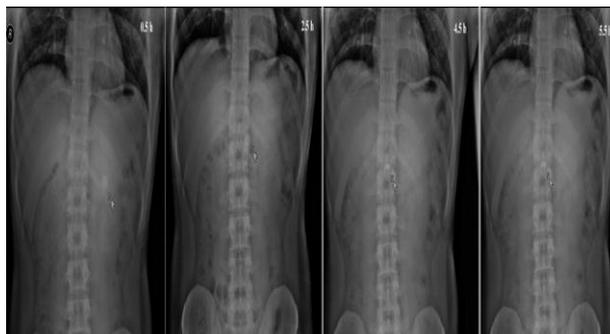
Radiographic images showing the presence of BaSO<sub>4</sub>-loaded floating-bioadhesive tablets of rebamipide in the stomach of volunteer-A at different time points (the location of the tablet is shown with an arrow).
